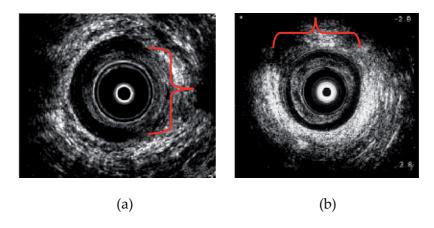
Close-up view of the anal sphincters at EAUS in the axial plane from two different patients: typical sonographic feature of the internal (a) and the external (b) anal sphincter defect which are seen as wide gaps (parenthesis) filled by fibrotic tissue showing moderate echogenicity and inhomogeneous hypoechogenicity, respectively. (Courtesy of dr. Favetta U.)
